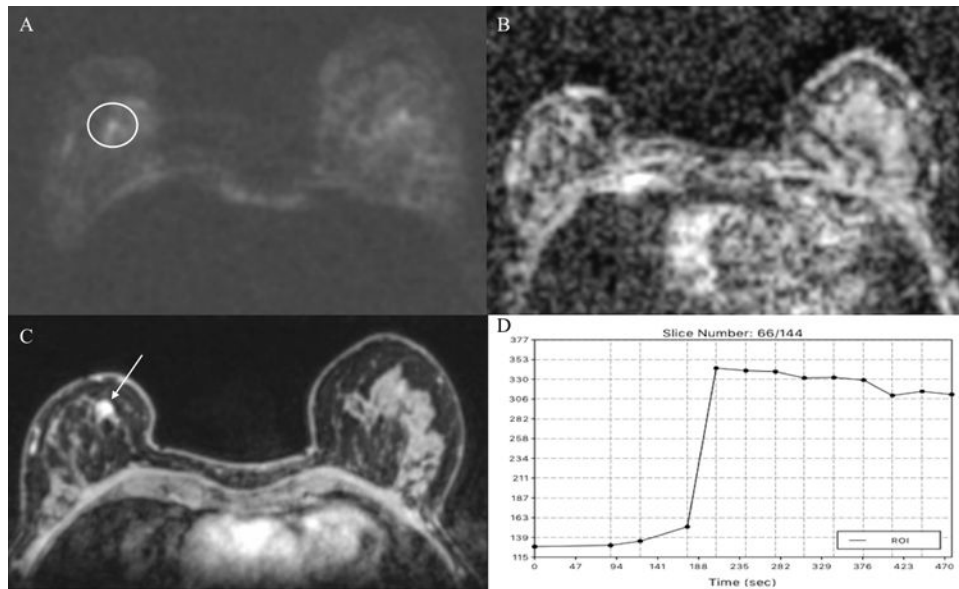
Invasive ductal carcinoma (IDC) grade 3 medially retro-areolar in the right breast in a 64-year-old woman: (A) On DWI in the high b-value images there is no restricted diffusivity or (B) decreased ADC values evident; DWI findings were classified as negative for malignancy. However, on DCE-MRI there is a (C) round and partly irregularly marginated mass 12 o'clock in the right breast (arrow) with (D) an initial fast slightly heterogeneous contrast enhancement followed by a plateau and was classified as BI-RADS 4. DWI was false negative.
